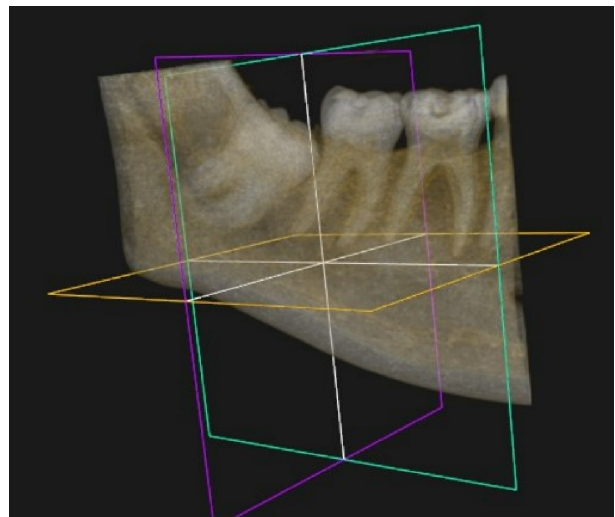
CBCT of impacted molar 48
